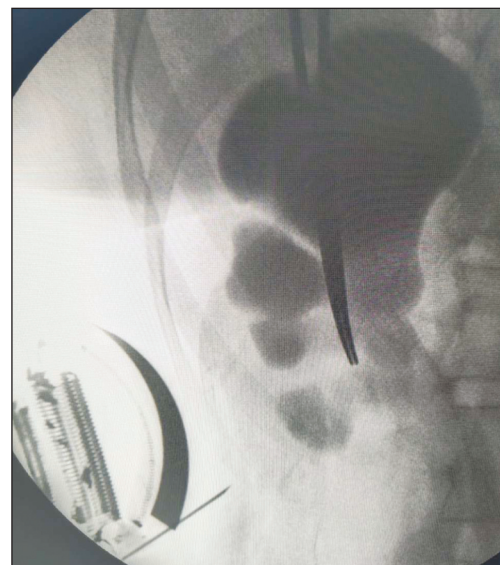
After stabilizing the ultrasound in the transverse plane, the needle was advanced towards the target calyx in the coronal plane under fluoroscopic guidance.
